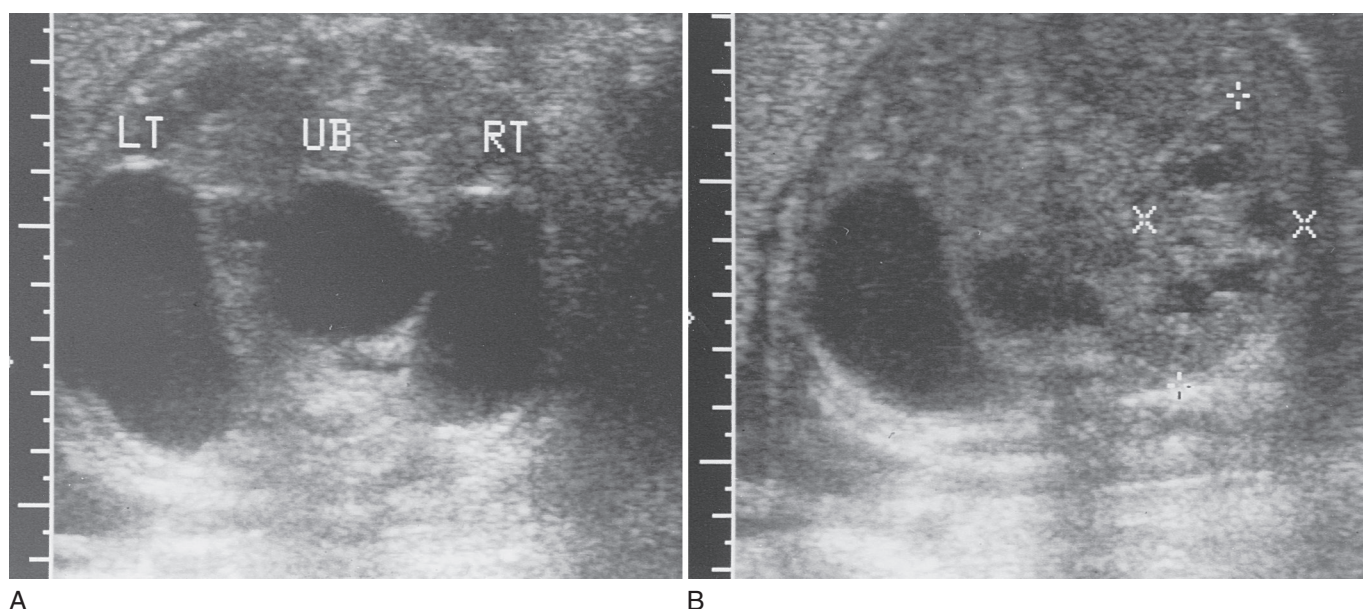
Fetal ultrasonography showing bilateral hydronephrosis. A, The urinary bladder (UB) is seen between the two dilated renal pelvises (LT and RT). B, The renal cortex is seen on the right side of the same fetus, between the two Xs.
